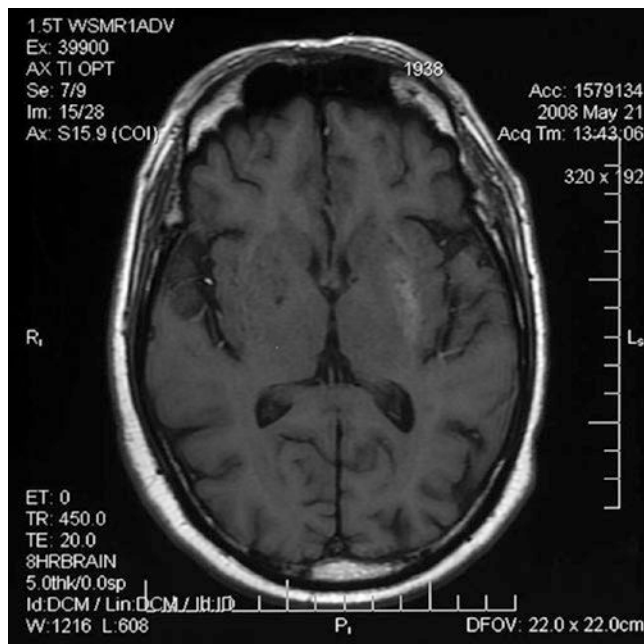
This T1-weighted MRI from another patient demonstrates abnormal signal in the right putamen in a patient with acute left hemiballismus due to hyperosmolar hyperglycemia
